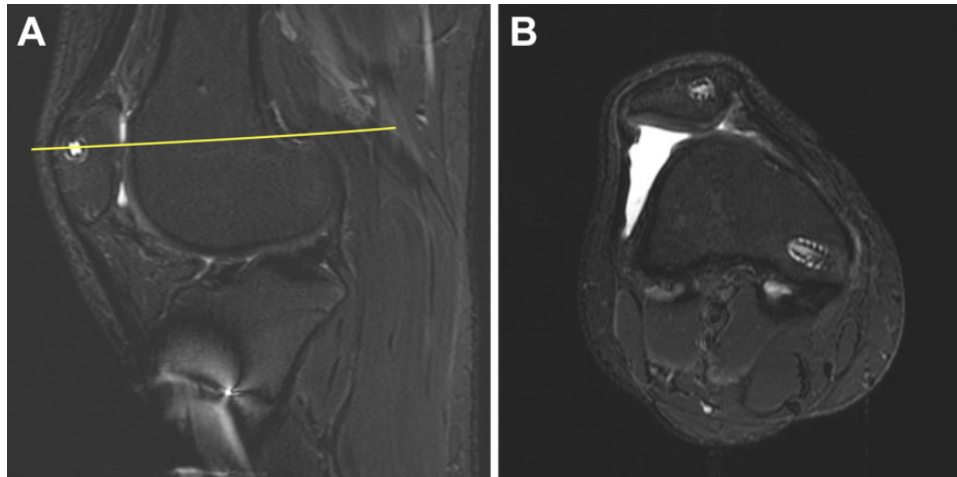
(A) Sagittal MRI scan with a reference line (yellow) through an area of proximal trochlear cartilage. This area of cartilage was proximal to the femoral condyles. (B) Corresponding axial MRI scan showing that this area of proximal trochlear cartilage on the distal femur had no formed posterior femoral condyles. MRI, magnetic resonance imaging.
